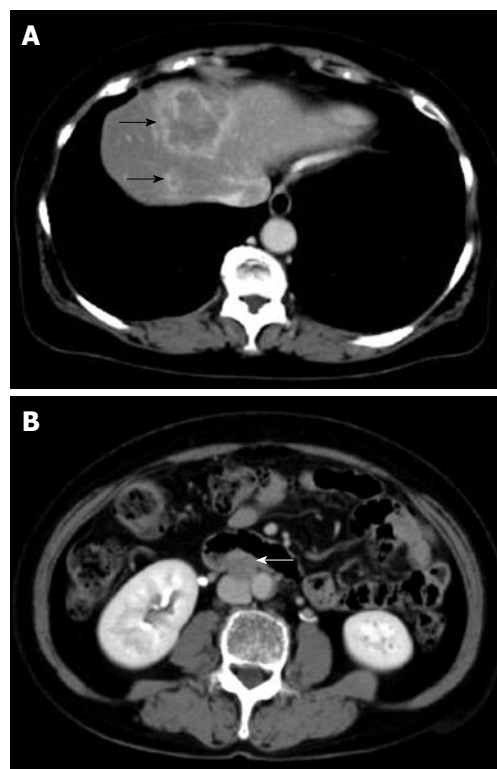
Computed tomography (CT) of the tumor on first admission. CT shows a low-density lesion with rim enhancement in segment VIII of the liver (black arrows) (A) and enlarged lymph node in the para-aorta (white arrow) (B).
